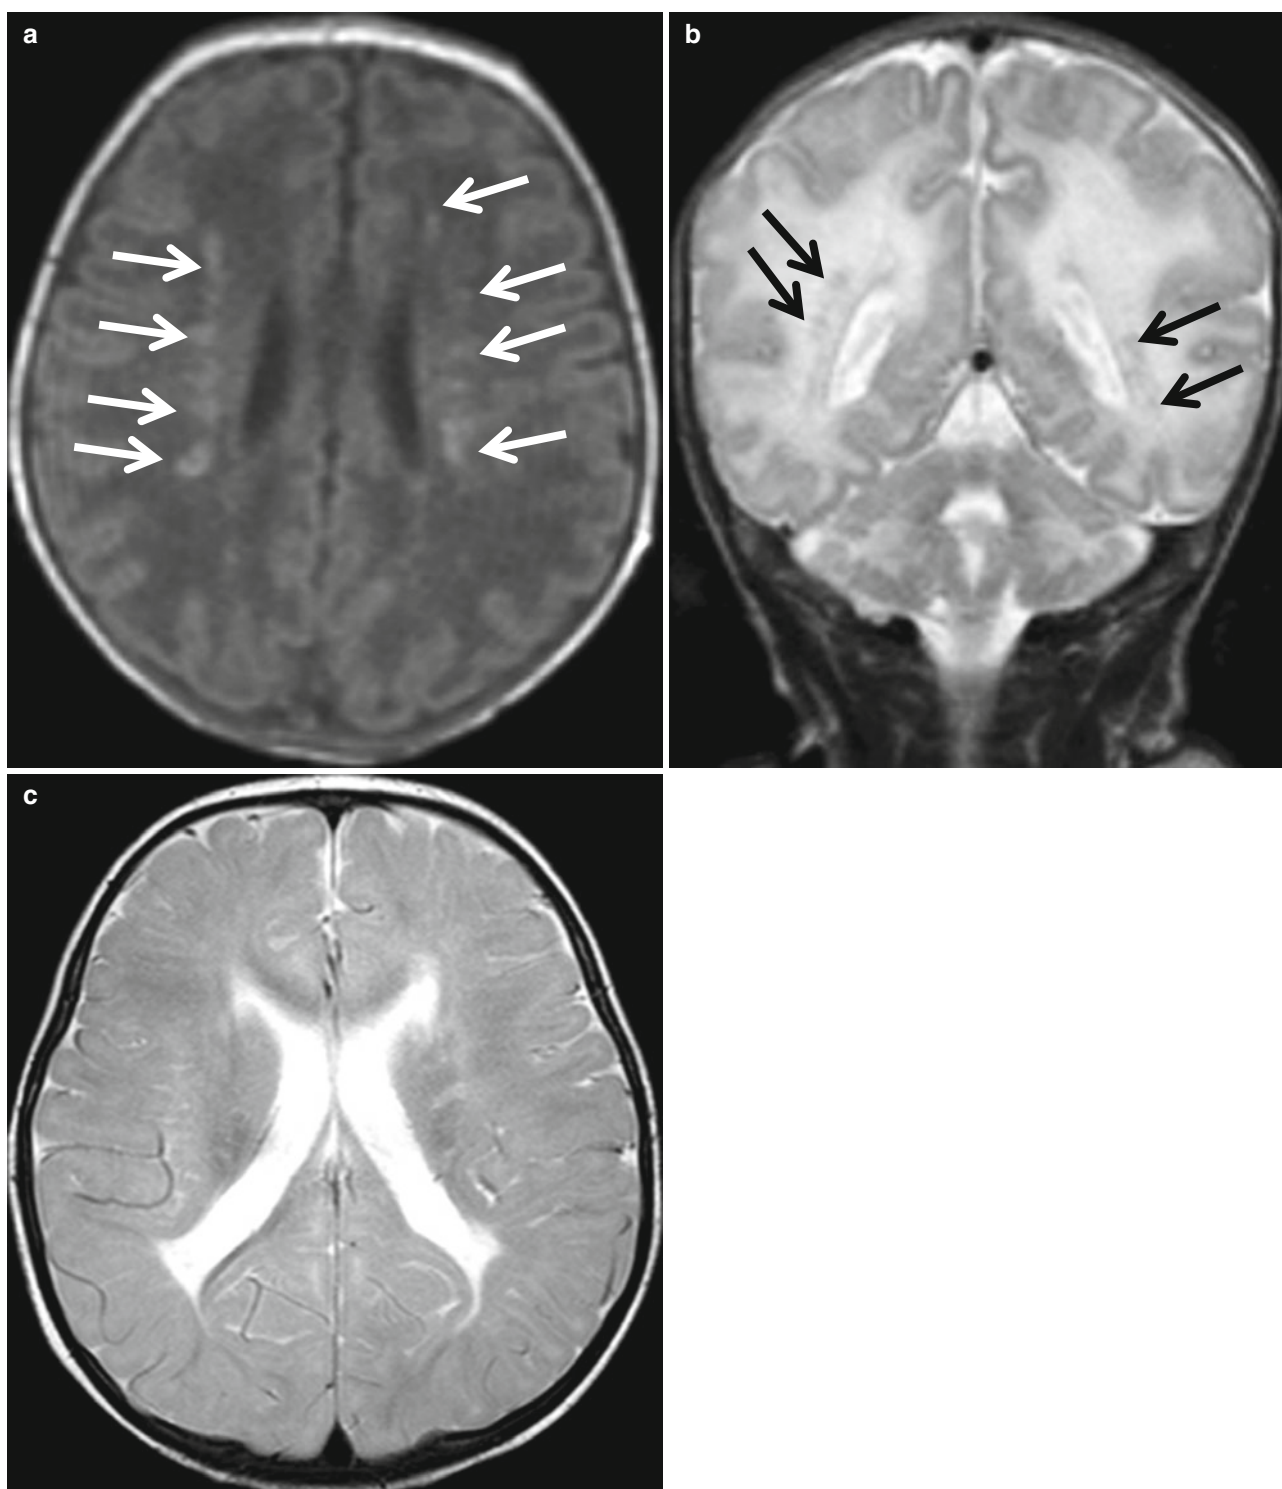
Noncavitary white matter lesions in preterm neonate. There are multiple punctate white matter lesions (*arrows*) becoming hyperintense on T1-weighted image (a) and hypointense on T2-weighted
